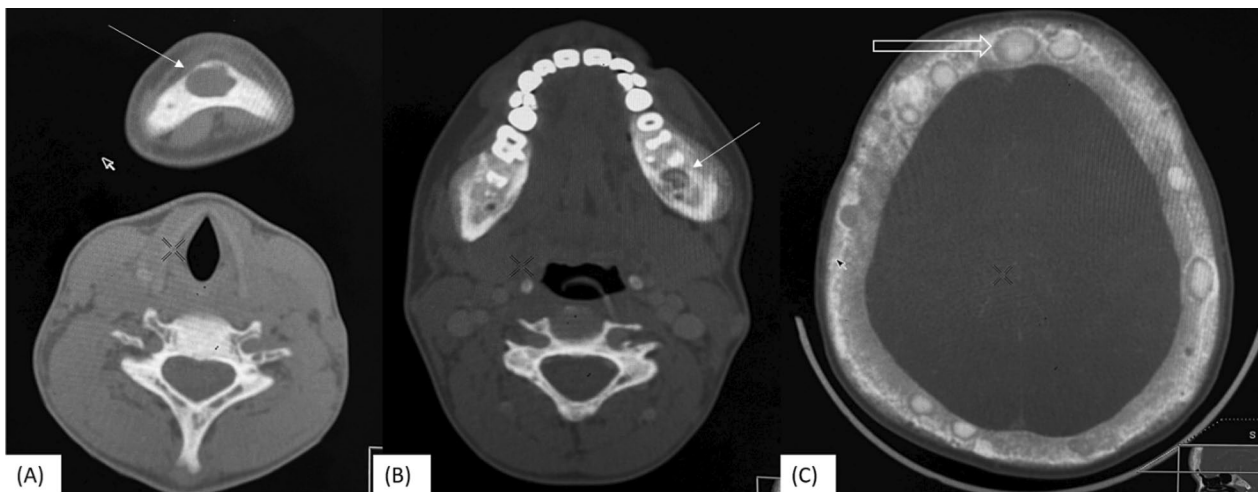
Non-contrast computed tomography images in axial section. A A well-defined, lytic lesion in the ramus of the mandible with subsequent expansion of the bony cortex, suggestive of a brown tumor (white arrow). B Another radiologically similar lytic lesion can be seen on the left side, near the base of the 2nd molar (white arrow). C Also, increased calvarial thickening with multiple focal areas of hyperdensities within it (white outline arrow) is not to be missed
